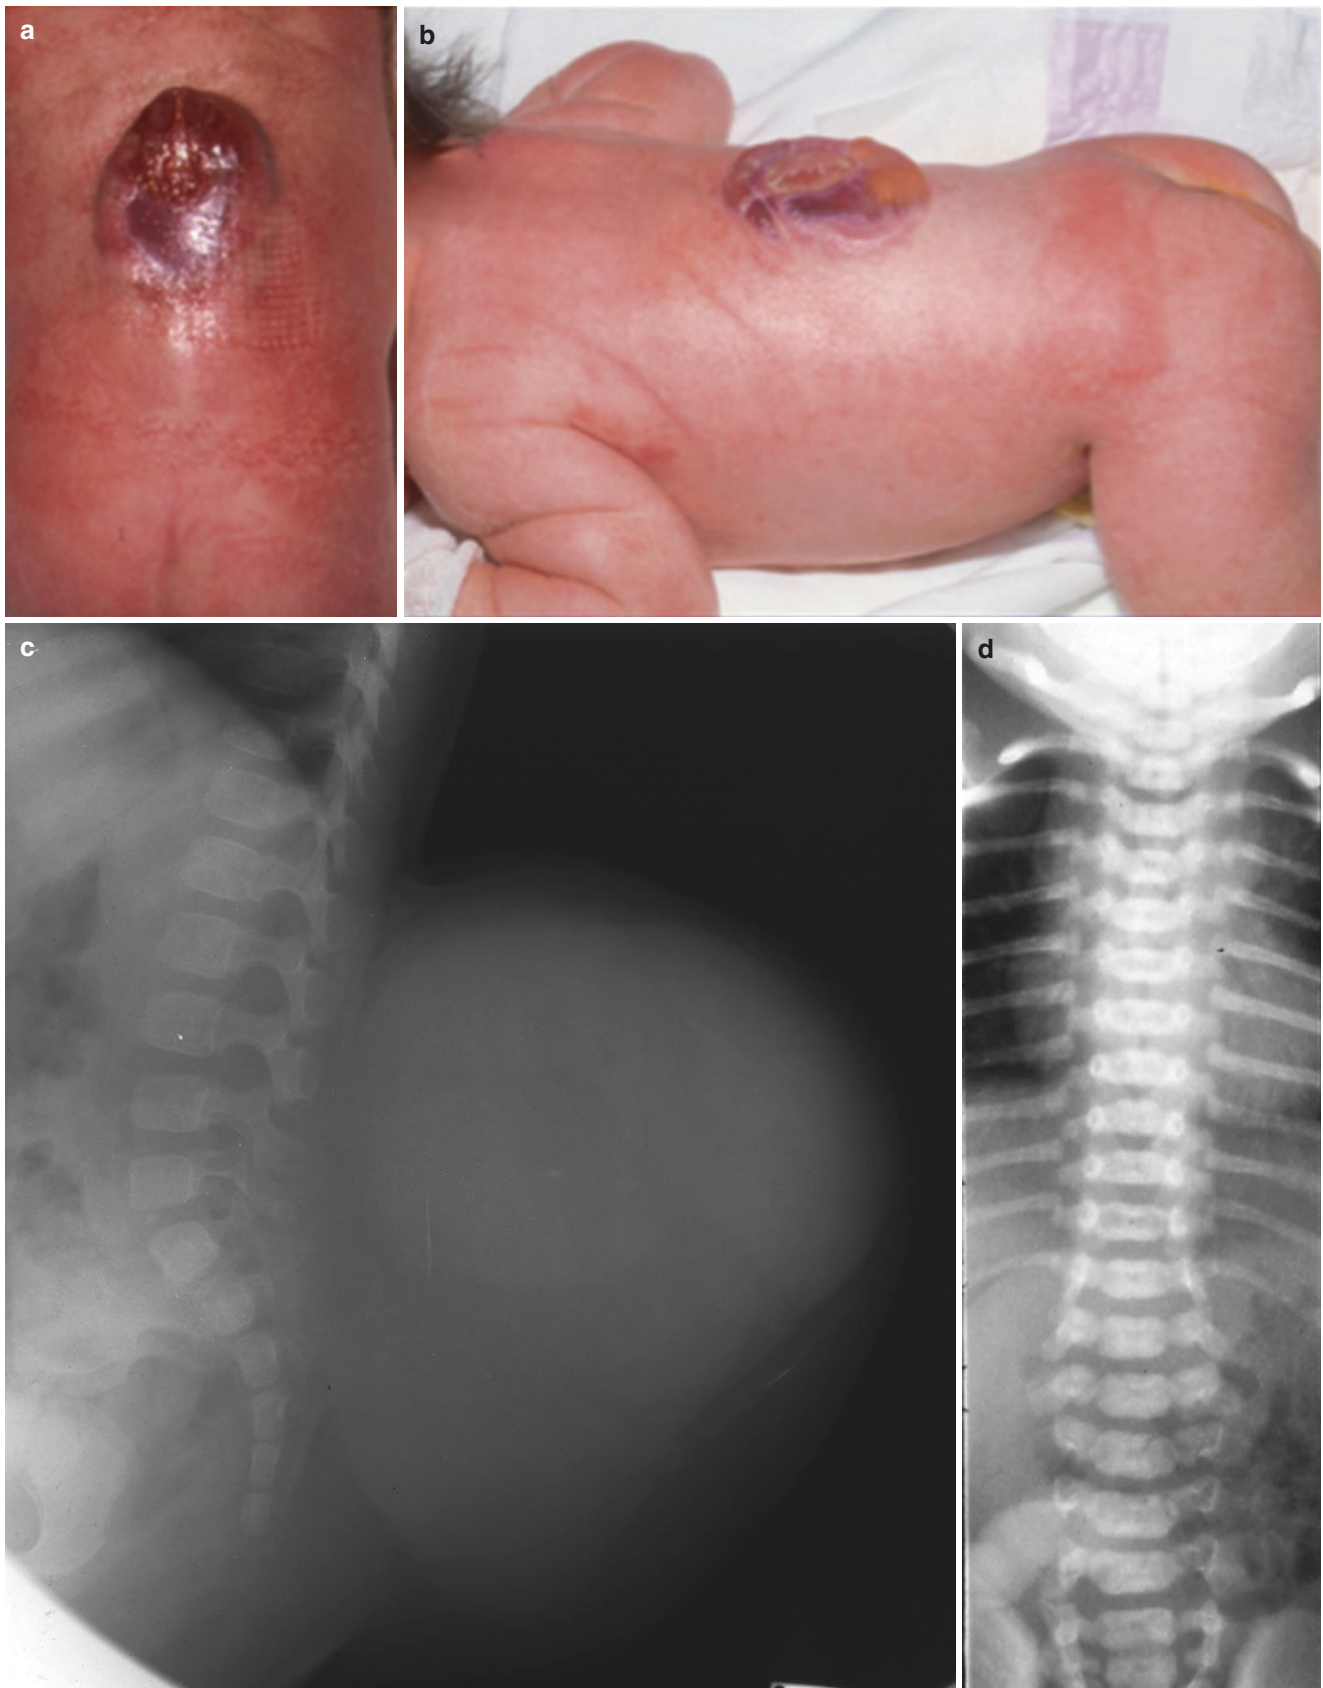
(a) Clinical photo of a lumbar myelomeningocele. An open lesion leaking CSF. (b) Later view of the same patient with a lumbar myelomeningocele. Note how there is loss of the normal curvature of the spine. (c) Plain X-ray of a lateral view of the spinal column of a
